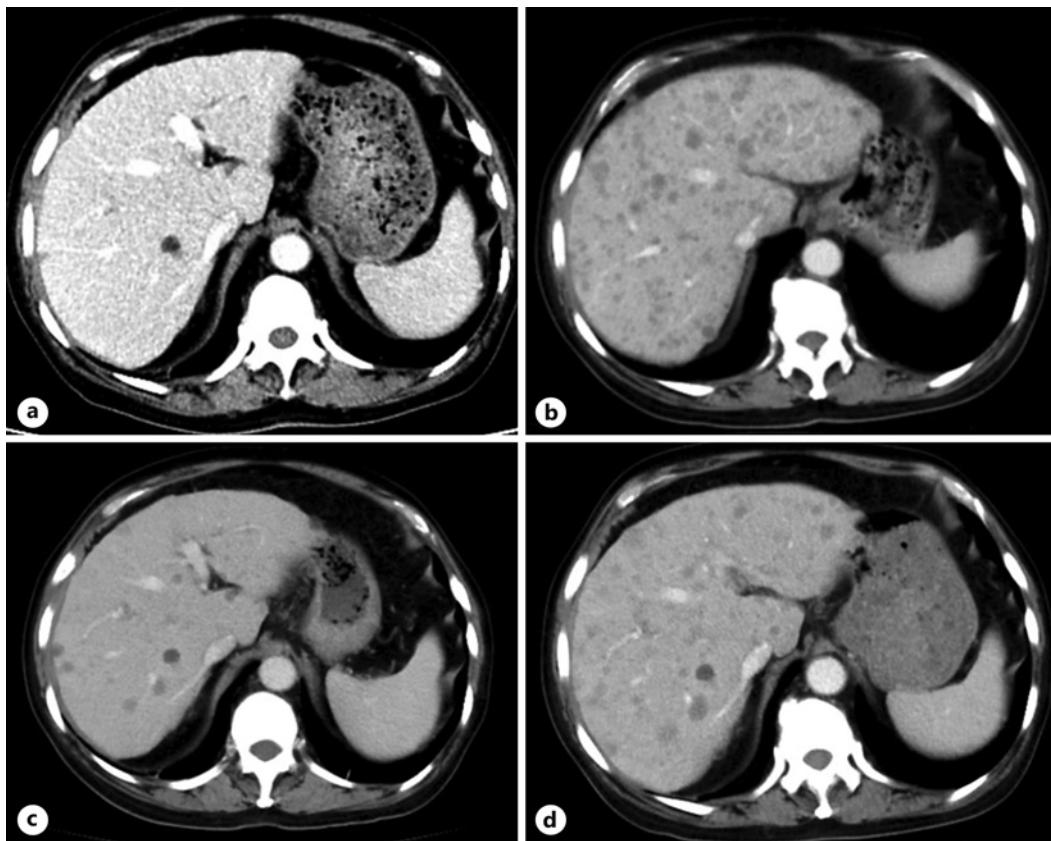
a On April 13, 2023, CT showed no metastasis of hepatic cysts. b On June 13, 2023, after the continuous increase of CEA, CA199, and CA125 for 9 months, CT showed diffuse multiple metastases in the liver. c After 3 cycles of etoposide combined with carboplatin chemotherapy, CT reexamination on August 17, 2023, showed that liver metastases were significantly reduced. d Reexamination of CT on September 12, 2023, showed that the liver metastasis increased again and the disease progressed.
